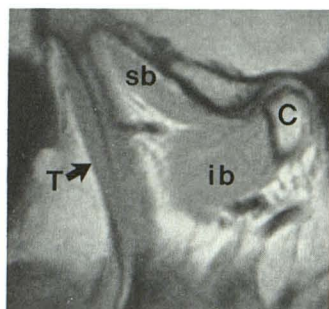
Correctly labeled masticatory muscles through medial aspect of temporomandibular joint. Sagittal, cephalometrically corrected, 3-mm-thick, proton-density MR image, 2200/20, through medial pole of mandibular condyle (C). Most medial aspect of temporalis muscle (T and arrow) is seen anterior to superior belly (sb) and inferior belly (ib) of lateral pterygoid muscle.
